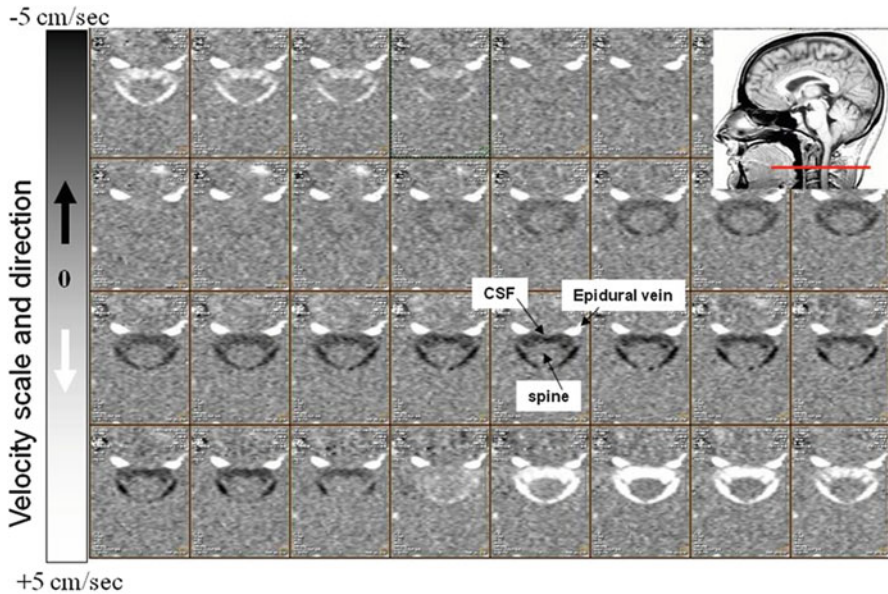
PC-MRI images of the CSF around the spine during one cardiac cycle. It is a visualisation of 32 images of cervical CSF flow around the spine during cardiac cycle. White pixels depict downward CSF flow flushing into the spinal canal, and black pixels correspond to upward motion of CSF filling the cranium
